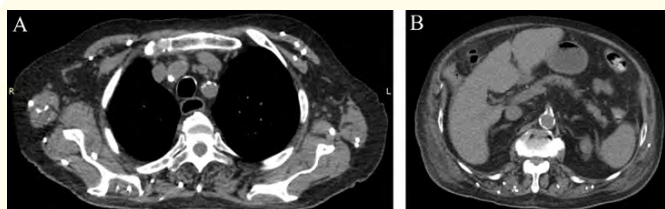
In A, axial section thorax CT scan demonstrating multiple muscle calcifications and calcified atheromatous plaques in the aorta. In B, axial section abdominal CT scan demonstrating multiple muscle calcifications and calcified atheromatous plaques in the aorta.
